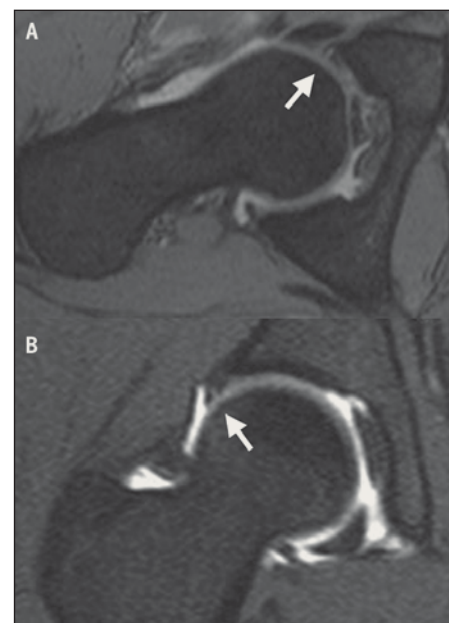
T2 axial oblique (A) and T1 coronal fat-saturated (B) magnetic resonance images demonstrating the presence of an anterior superior labral tear (arrow).
